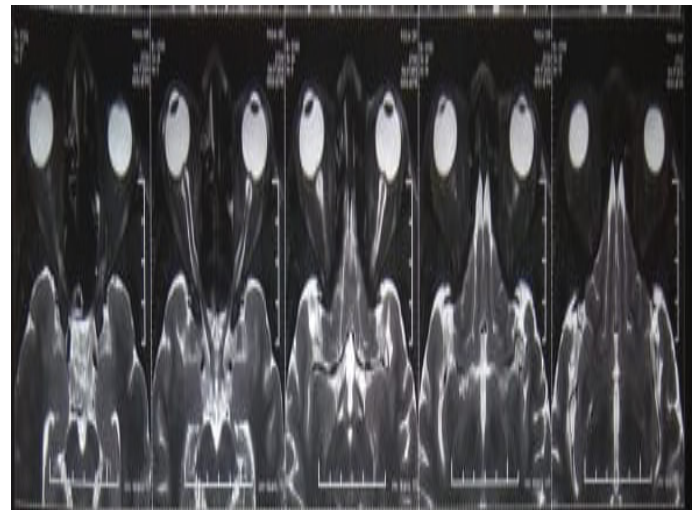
MRI orbit with contrast showing T2 HI in intracranial optic nerves.
